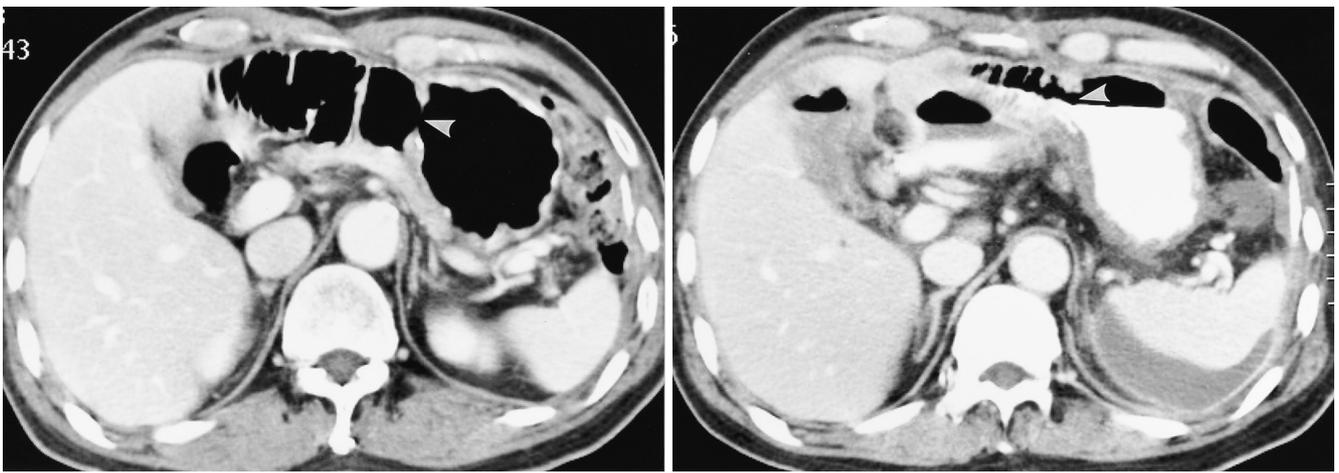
Good distention of both jejunal and gastric lumens on multidetector-row CT using effervescent granules. On multidetector-row CT scan using effervescent granules as an oral contrast media, both jejunal (A) and gastric remnant lumens (B) demonstrated good distention.
